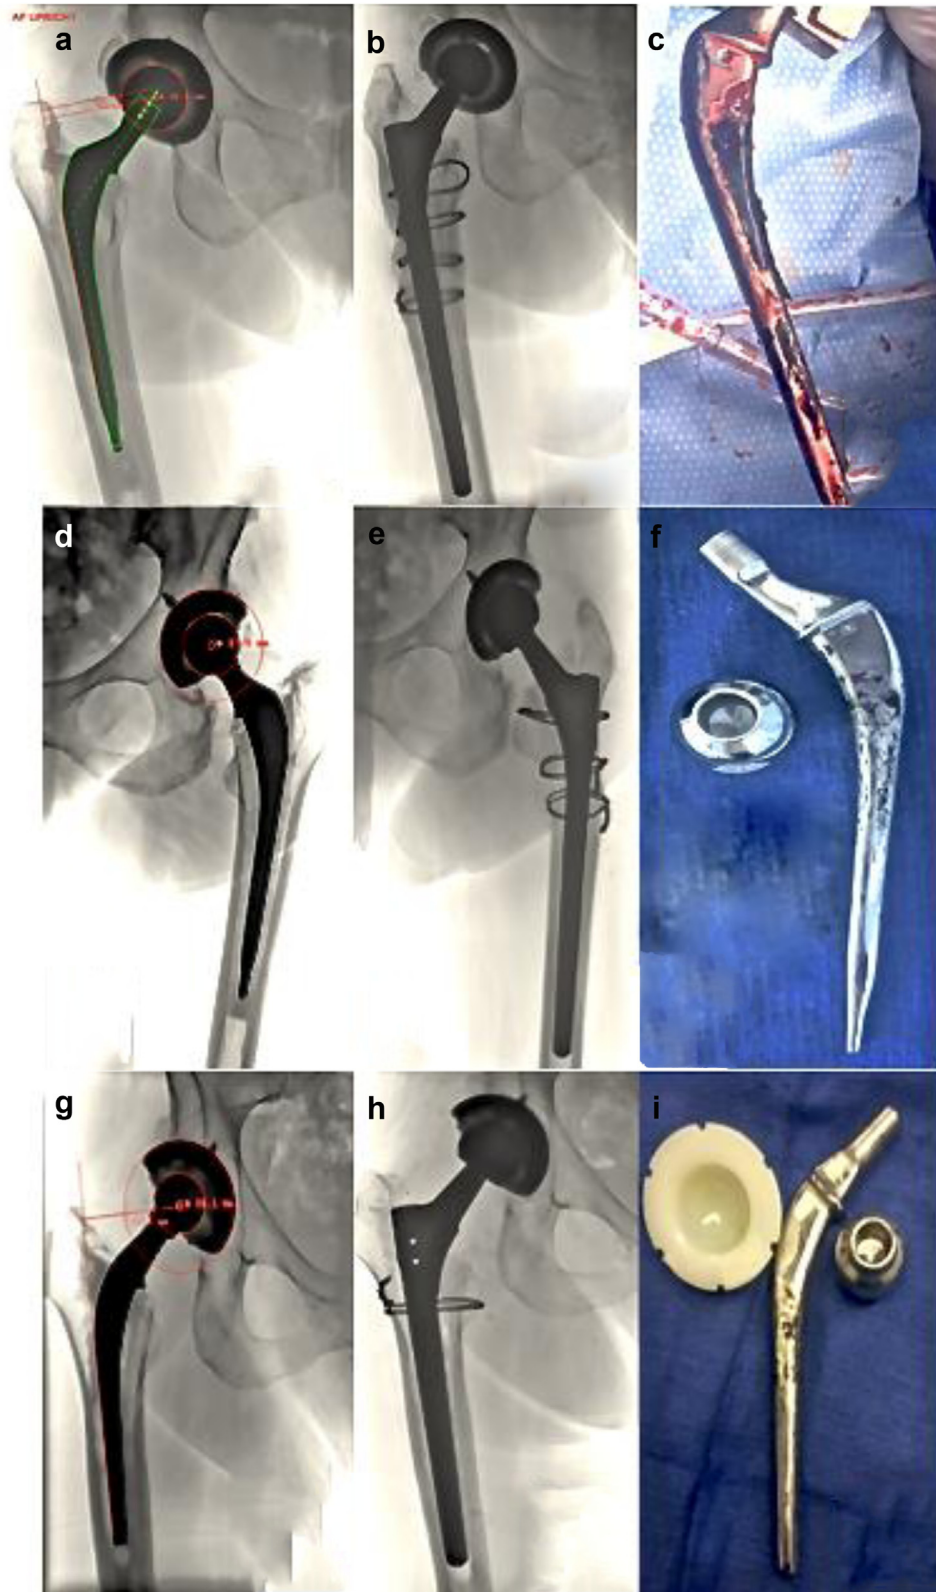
Figure 1. (a) Pre-revision radiograph case 1 shows no measurable polyethylene wear and well fixed stem, (b) case one radiograph post revision to pressfit titanium stem and ceramic head, (c) case 1 primary Heritage stem intra-operative photograph showing gross corrosion of cobalt-chromium cement interface, (d) Pre-revision radiograph case 2 showing no appreciable polyethylene wear and well fixed stem, (e) Post-revision radiograph case 2 showing revision to titanium pressfit stem and ceramic head, (f) Intraoperative photograph of extracted Heritage stem showing corrosion at cemented surfaces, (g) Prerevision radiograph case 3 showing minimal polyethylene wear and well fixed stem, (h) Postrevision radiograph showing revision of stem to pressfit titanium, head to 32 mm ceramic, and liner to crosslinked polyethylene, (i) Case 3 explanted components, Heritage stem shows corrosion of cemented surfaces.
